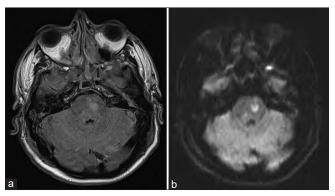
Magnetic resonance imaging brain (MRI) demonstrating (a) focal area of hyperintensity in the left pons on axial fluid attenuated inversion recovery and (b) corresponding diffusion restriction on diffusion-weighted imaging.
